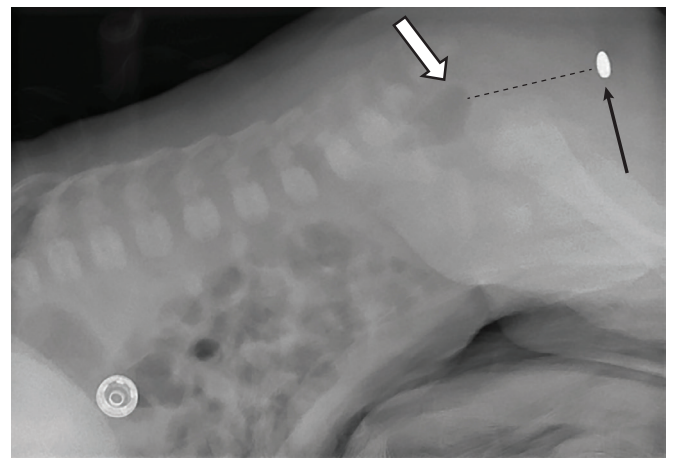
X-ray imaging of the abdomen with a horizontal beam of rays in a newborn with anorectal malformation. The black arrow indicates a radiopaque marking on the skin where the anal opening should be present. The hollow arrow indicates the gas-filled blind end of rectum.
